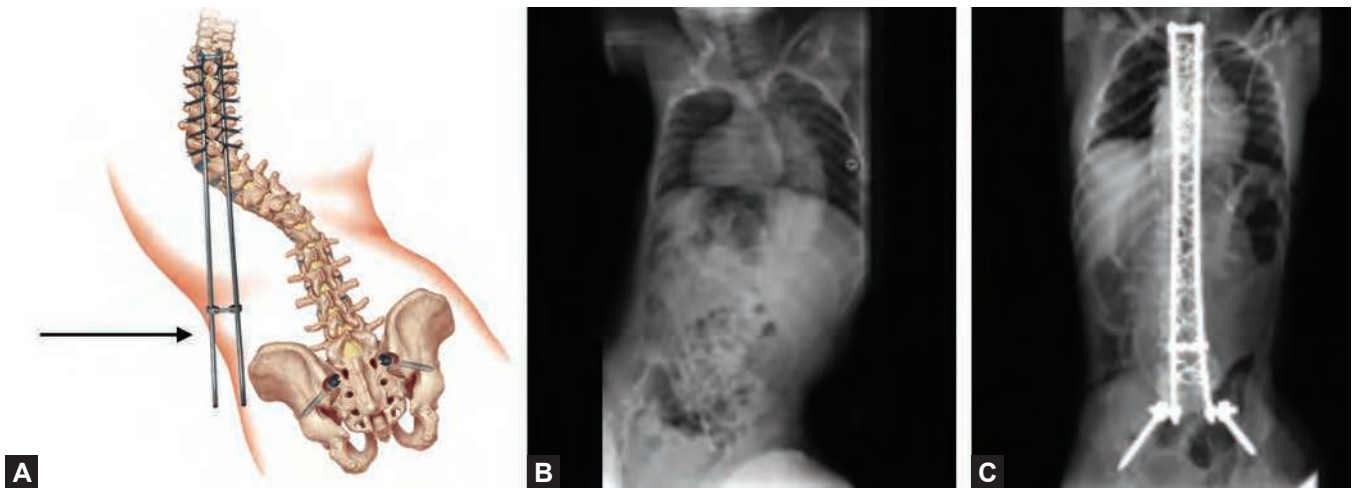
Radiographs of a boy with hyperlordosis before and after surgical correction.
